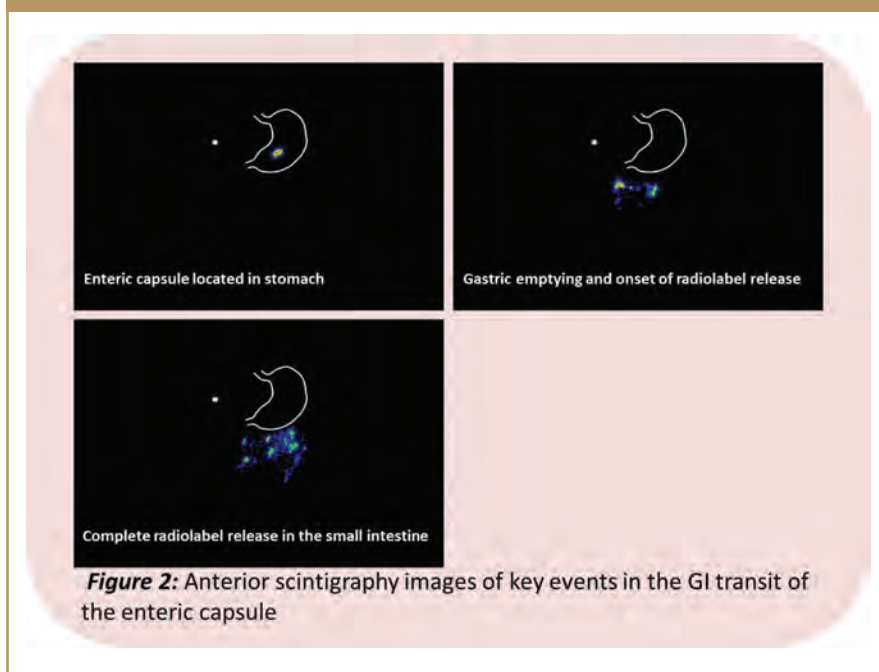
Anterior scintigraphy images of key events in the GI transit of the enteric capsule
